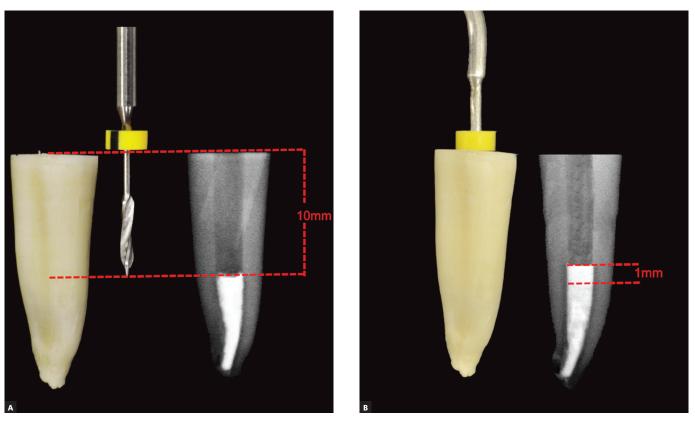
A) Partial desobturation of 10mm of depth with a #3 Largo Bur. B) 1mm accommodation of the Coltosol® plug over the remaining obturation, with a rubber stopper cursor adjusted to the desired length, radiographically confirmed.
